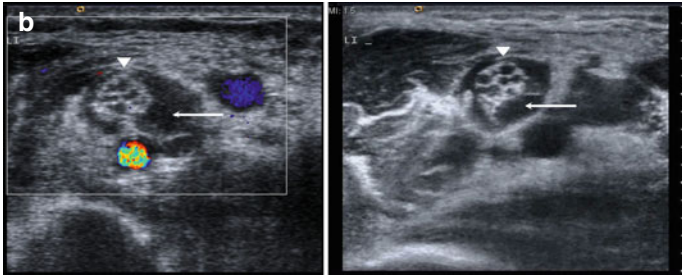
(a) Entrapment of median nerve at the axilla by a poorly customized arm prosthesis followed by axonal loss due to the compression of both the median and musculocutaneous (not shown) nerves. (b) Corresponding ultrasound images demonstrating a flattening (*arrows*) of the median nerve (*arrowheads*) at the site of compression as well as a nerve swelling proximally and distally to the lesion
